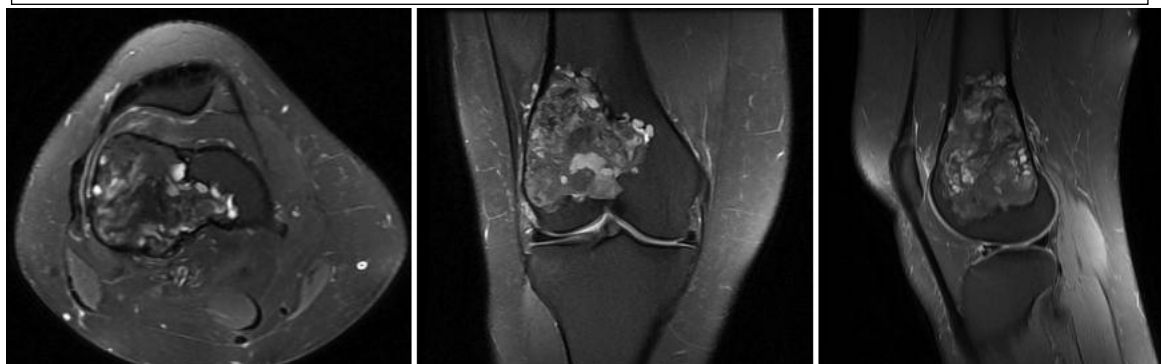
MRI showing mixed lesion involving lateral condyle of distal femur
